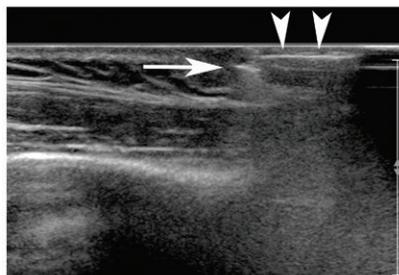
Portion of a piercing lost below the skin in a 19-year-old woman. (a) Radiograph shows a small piece of metal (arrowhead) in the left shoulder. An attempted removal by palpation was unsuccessful. (b) US image shows a hyperechogenic finding with reverberation artifact, corresponding to the metal fragment (arrow). (c) US image obtained during the US-guided removal procedure shows Halsted mosquito forceps (arrowheads) aimed toward the foreign body (arrow). (d) Photograph shows the removed metal fragment, with a pen lid included for size comparison.
